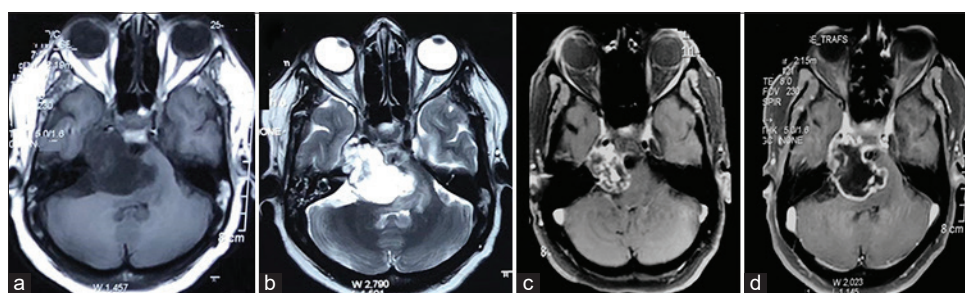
(a) MR images showing enlargement of tumor on T1, (b) T2, (c) and (d) sequences with areas of cystic changes and irregular contrast enhancement.
